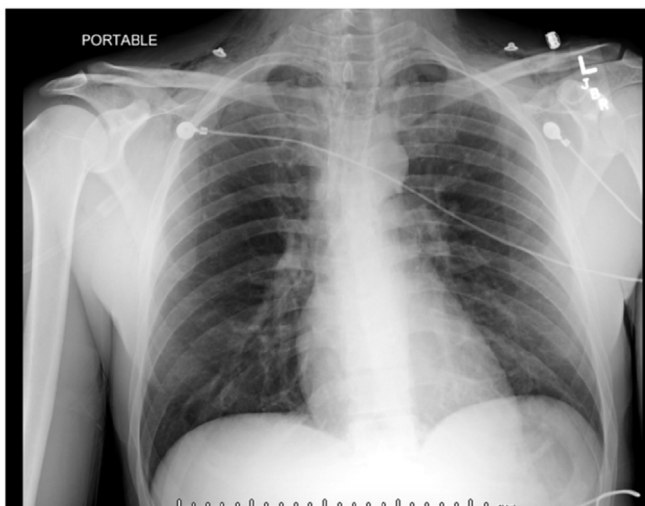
Chest radiograph showing mediastinal air with extensive subcutaneous gas present.
